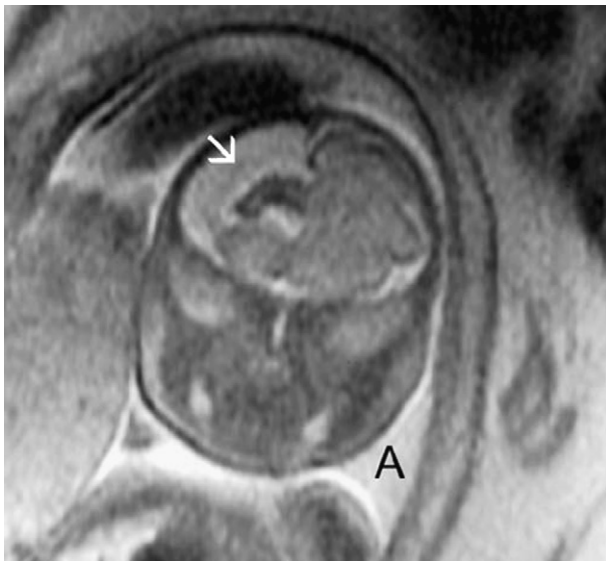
A 31-year-old woman at 28 weeks' gestation with a monochorionic, diamniotic twin pregnancy. Co-twin demise was confirmed two weeks prior to the magnetic resonance imaging. A large porencephalic defect (arrow), likely secondary to ischaemic injury, is demonstrated in the brain of surviving twin A on a coronal T2-weighted image. Demise of co-twin B, with twin embolic disease, was thought to be the cause of the porencephalic changes. Reproduced with kind permission from Springer Science and Business Media: Hu et al.³⁸
